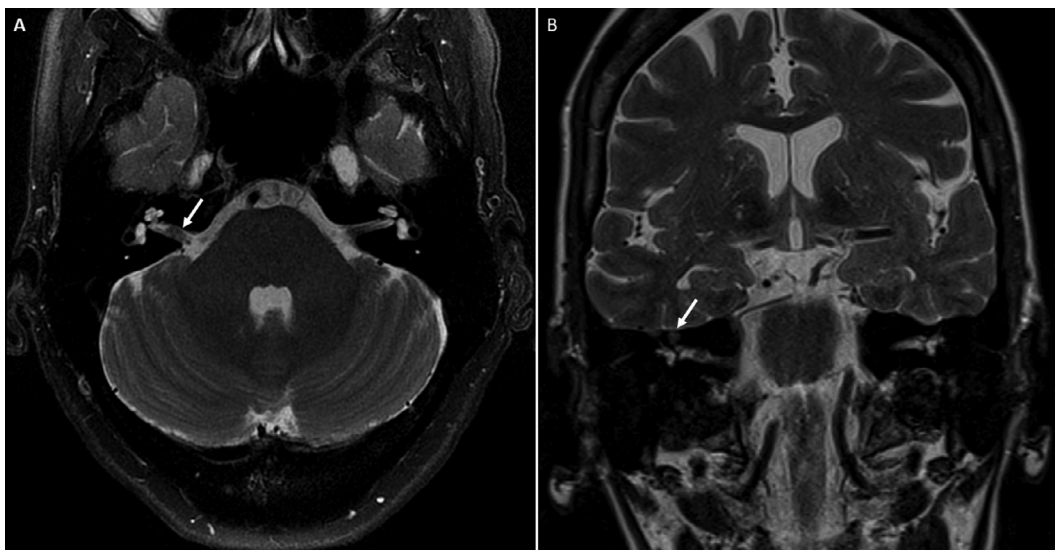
Axial (A) and coronal (B) T2-weighted images showing internal auditory canal (A, arrow) and geniculate ganglion (B, arrow) in a 57-year-old woman with recurrent episodes of dizziness over 6 months. The lesions demonstrate intrinsic T2 hyperintense signal characteristics.
